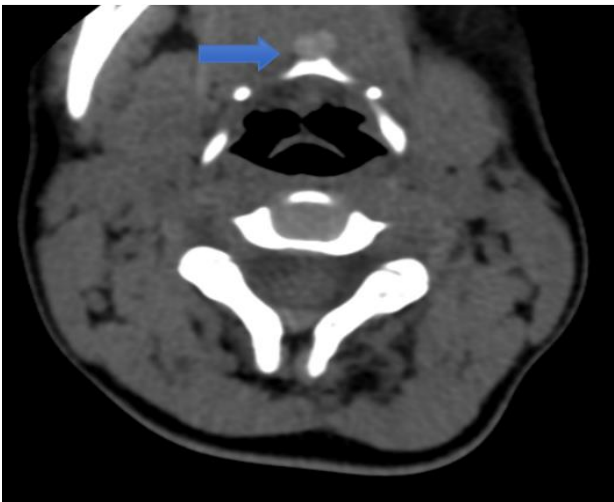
Axial CT neck of ectopic thyroid at the suprahyoid region.
